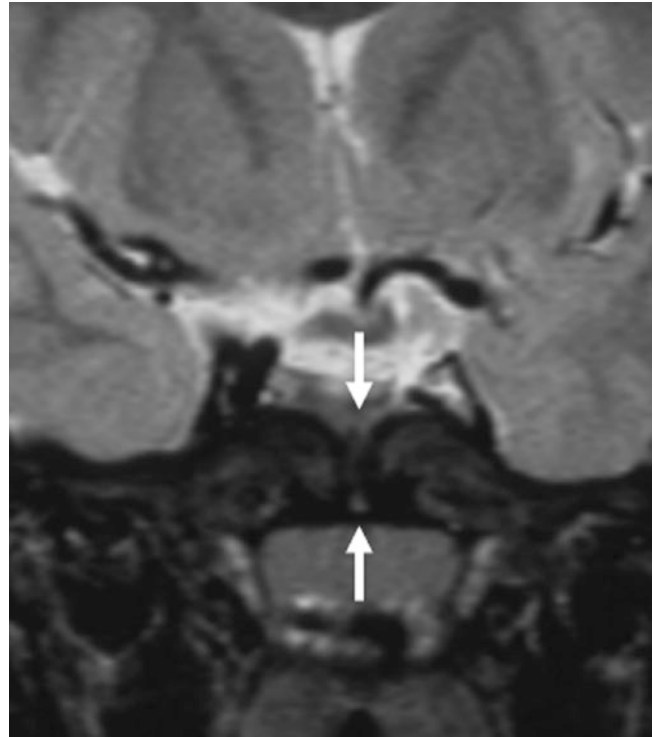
A 6 year old with a coronal T2WI MRI that shows the patent extent of a PF/CPC (arrows)
